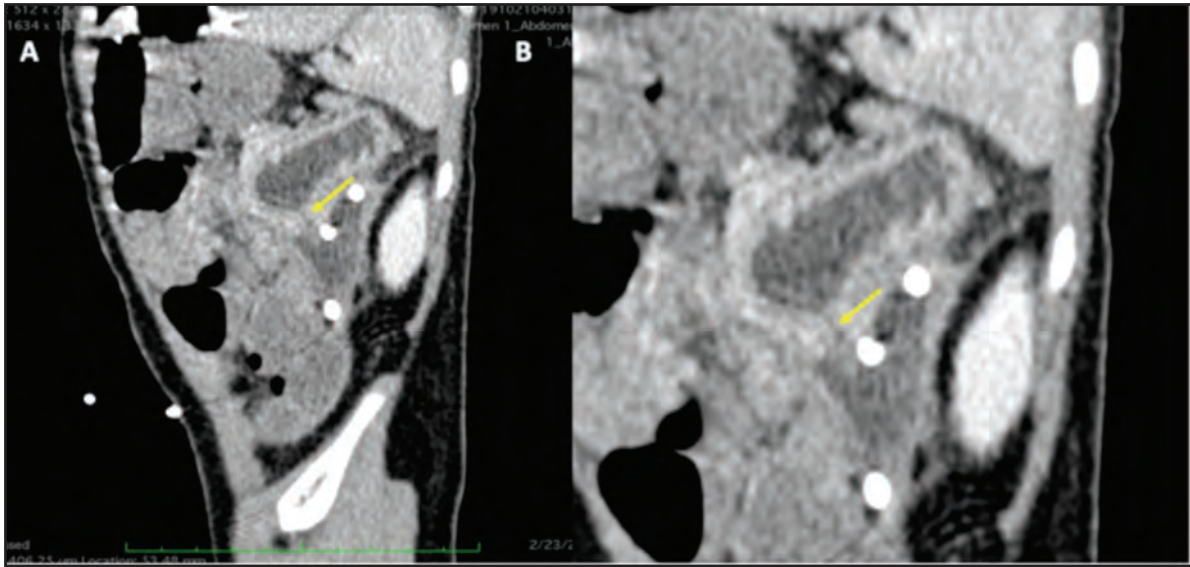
Contrast-enhanced CT abdomen on sagittal reconstruction showed a focal wall defect at the inferior aspect of the cystic lesion which communicates with the left retroperitoneal collection (A, B). Note the corrugated appearance of the wall of the cystic lesion resembling the gastric wall (B).
